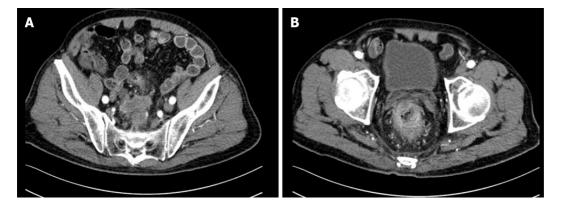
Preoperative contrast-enhanced computed tomography imaging scans. A: Computed tomography (CT) image showed the rectal lesion located in the upper rectum; B: CT image showed a lesion breaking through the adventitia.
